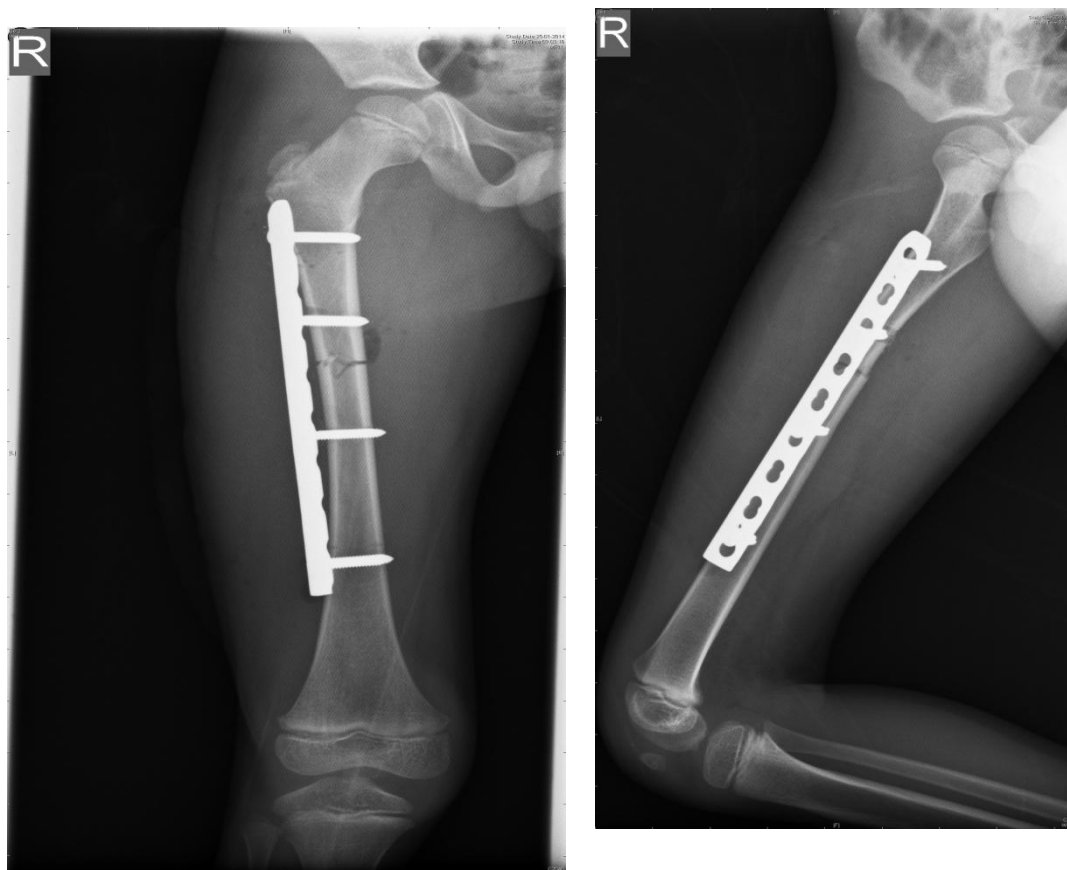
Radiographs showing union in both views
